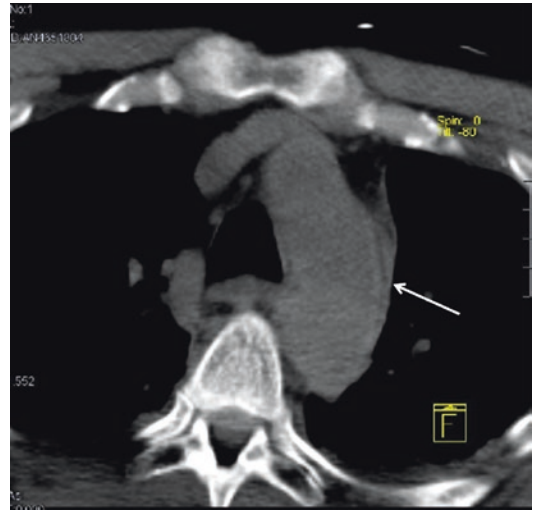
Axial CT scan shows mediastinal hematoma (white arrow shows preserved periaortic fat plane)
